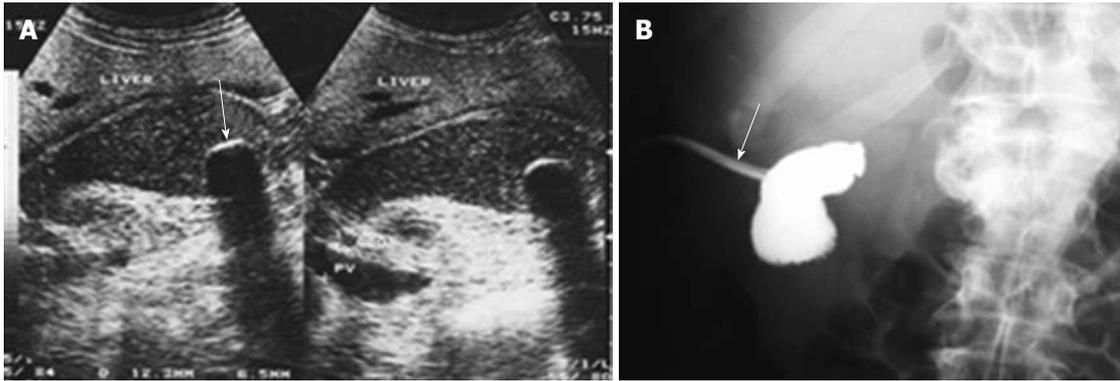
A case of acute calculous cholecystitis. A: Abdominal sonography shows thickening and stripping of its wall with stones and biliary mud seen within its lumen (arrow); B: Fluoroscopy image after ultrasonography-guided percutaneous cholecystostomy shows good position of the drainage tube (arrow).
